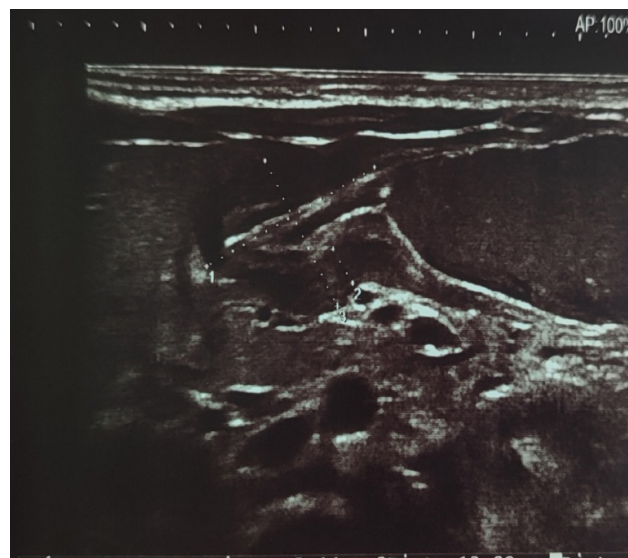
Ultrasound image of pyloric stenosis.
